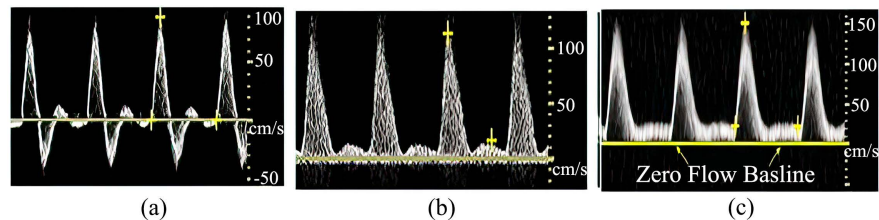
Vascular color Doppler ultrasound images for lower extremity arteries [22]. (a) Triphasic: Normal blood flow and no atherosclerosis or plaque or calcification. Three phases—forward flow, flow reversal, and a second forward component. (b) Biphasic: Light to moderate. Atherosclerosis plaques but normal blood flow. Two phases—one forward flow and one reverse. (c) Monophasic: Abnormal. stenosis with a diameter reduction $> 50\%$. One phase, No flow reversal, and no second forward component.
